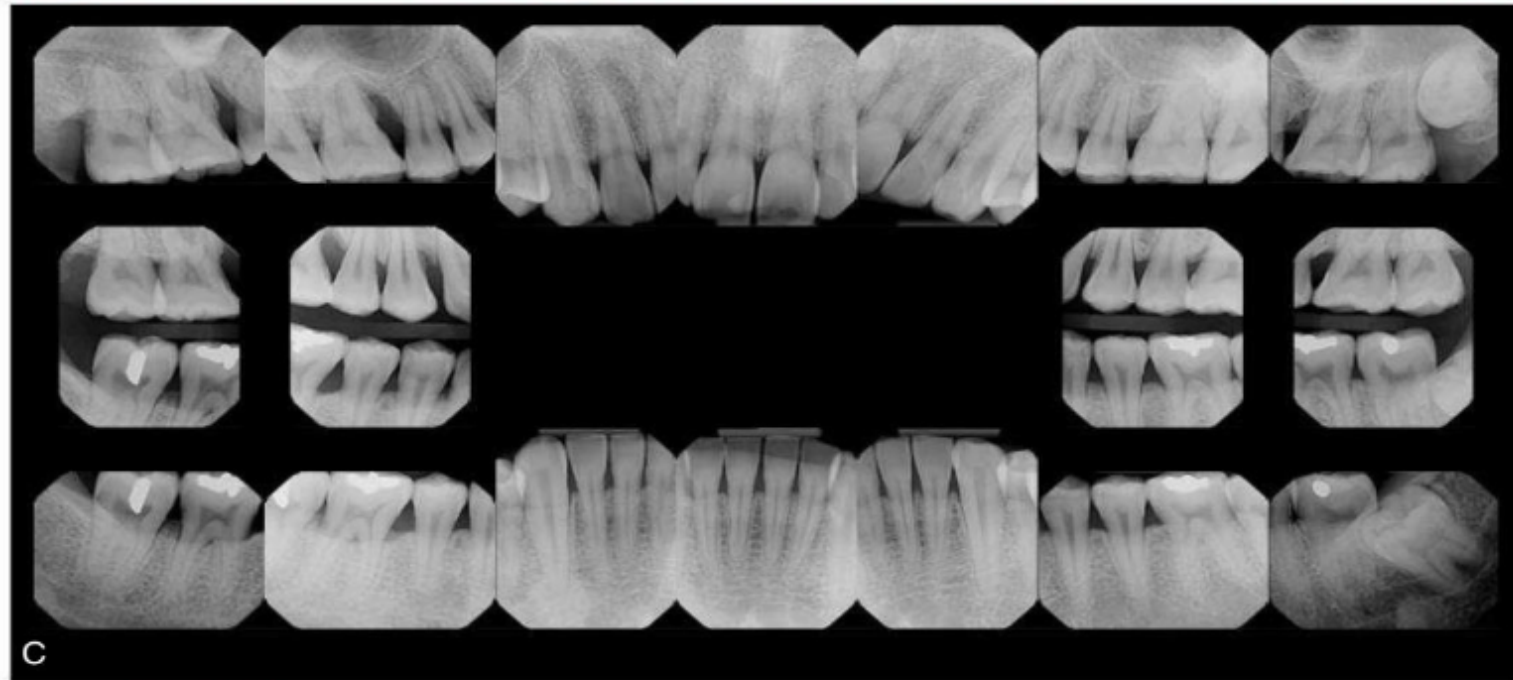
Clinical photos (A and B) and full mouth radiographic series (C) of a patient who had molar-incisor pattern of periodontitis (used to be called "localized aggressive periodontitis"). The overall prognosis is favorable except for the maxillary right first molar (unfavorable), maxillary left first molar (questionable), and mandibular right first molar (questionable).
